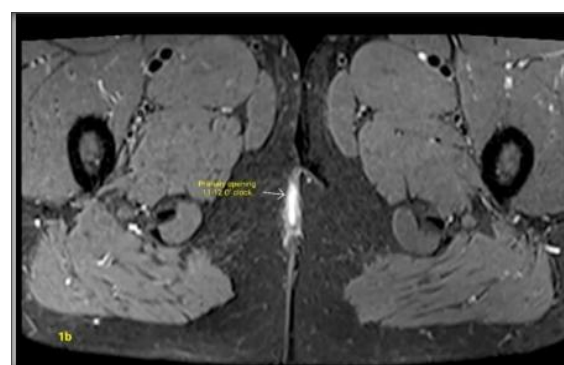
T1 wtd MRI image demonstrates linear IR hyperintense tract with external opening at 11-12 o'clock position
